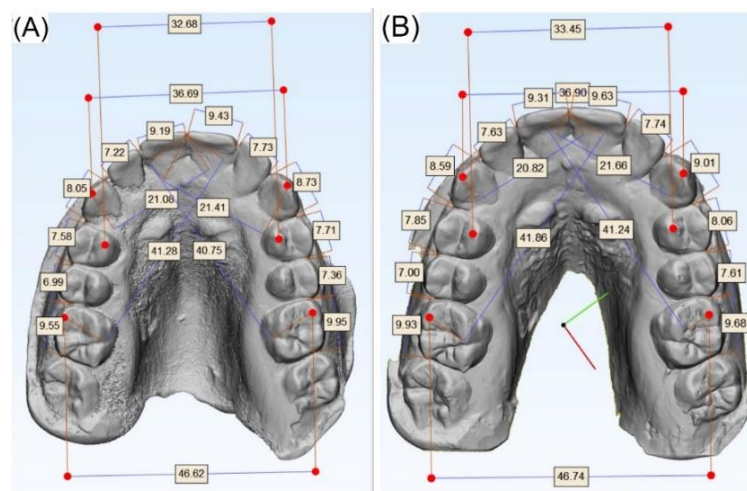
Identification of the landmarks on the digital model. (A) Showing measurements obtained from CBCT. (B) Showing measurements obtained from EOS.
